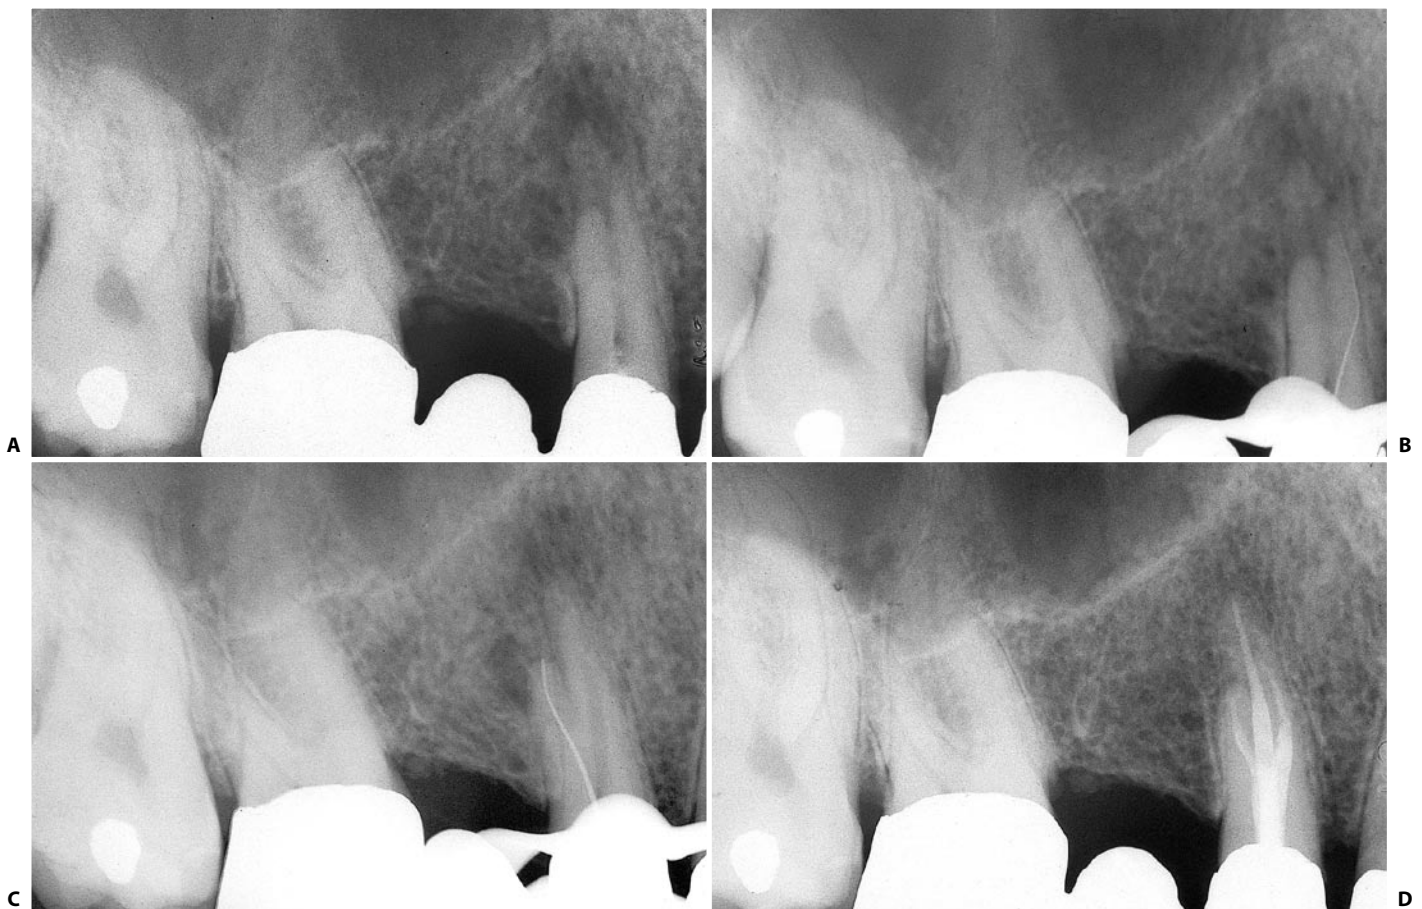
A. Preoperative radiograph of an upper right first premolar. In the presence of fused roots, it may not be easy to detect the presence of three canals. B. The first instrument introduced in what seems to be the only buccal opening appears eccentric with respect to the shadow of the root. More precisely, it appears mesially displaced: the instrument has entered the mesiobuccal canal. C. Introduced into the same orifice with a distally-facing precurvature, the instrument automatically enters the distobuccal canal. D. Thirty-four months later, this radiograph shows the presence of three canals, as well as healing.
